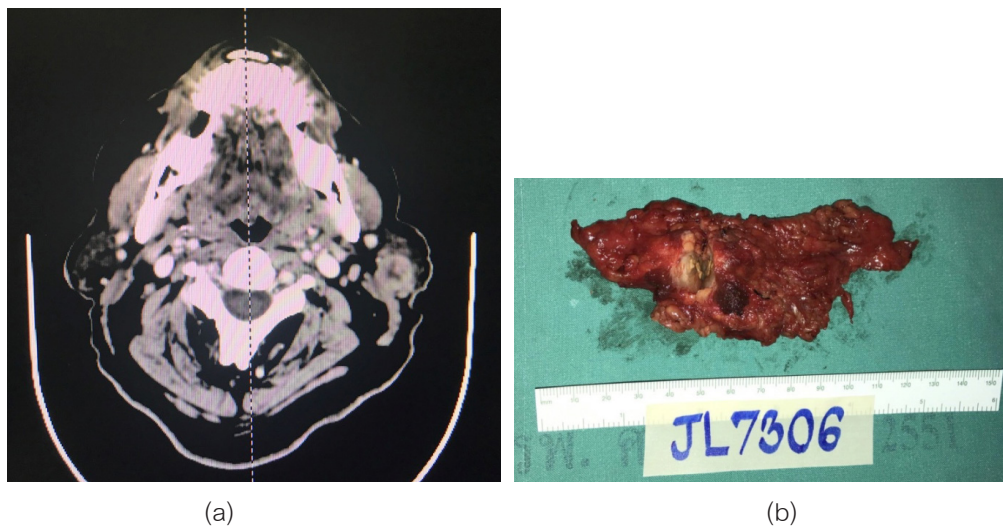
(a) Lobular-contoured solid mass in the anterior lobe of the right parotid gland (4 × 2.5 cm in size) in the patient's computed tomography (CT). (b) The lesion invading temporozygomatic and buccal branches of the facial nerve and originating from the superficial lobe of the parotid gland.
